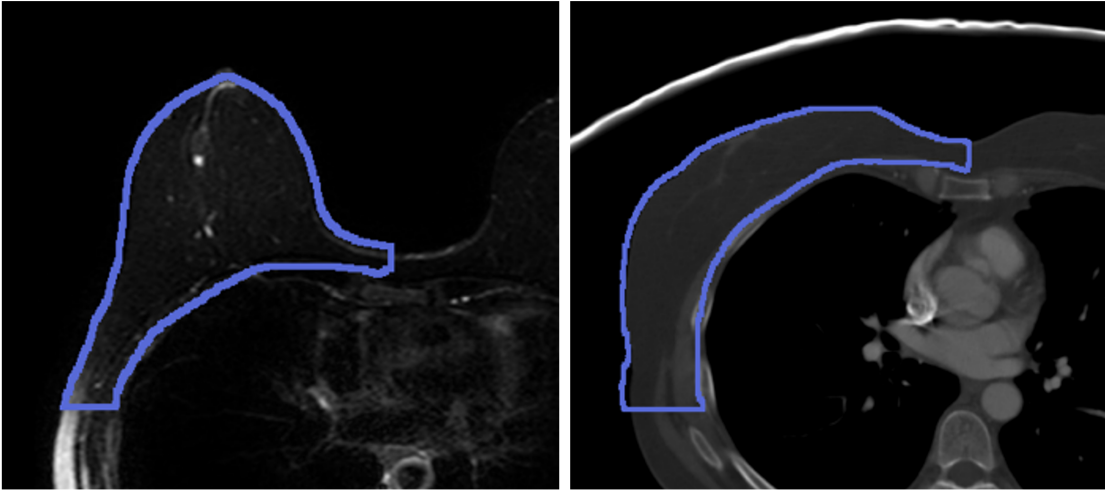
Left: prone MR image and breast contour. Right: supine CT image and breast contour.
